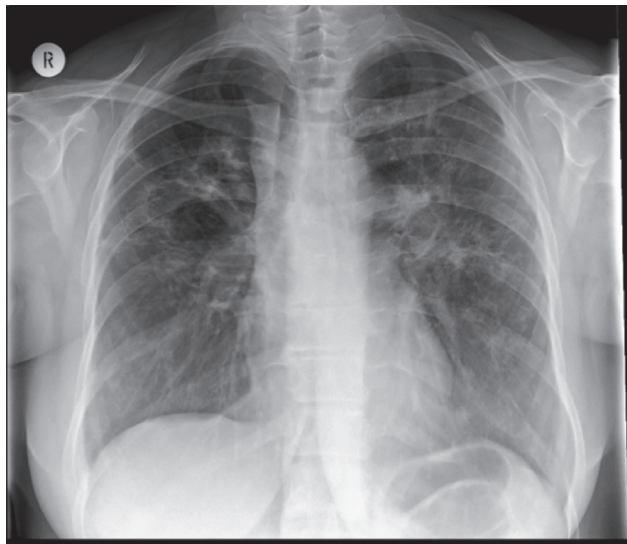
Chest radiograph of the same patient noting stable interstitial lung shadowing – it was unclear without the PET CT scan if the patient's sarcoidosis was still 'active' and required ongoing treatment.
